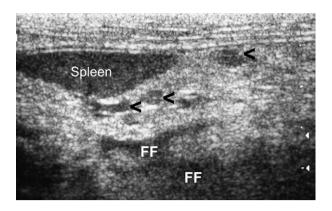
Ultrasonography of the abdomen. Hyperechoic omentum with hypoechoic foci (arrowheads). FF, free fluid.
